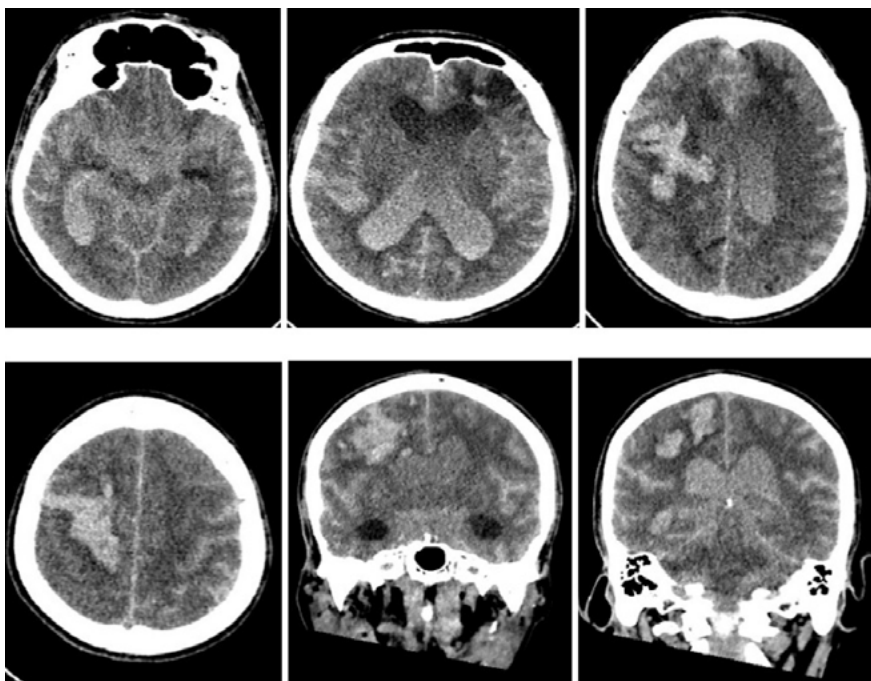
Non-contrast computed tomography of the skull showing extensive intracerebral hemorrhage.
